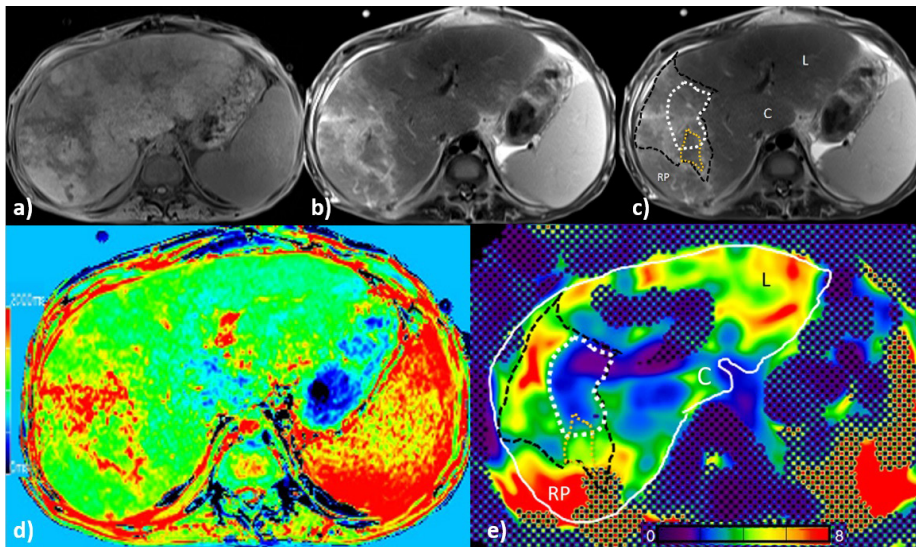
Magnetic resonance (MR) images acquired from a 24-year-old man with occluded right and middle hepatic veins and inferior vena cava. (a) Axial T1-weighted image (T1WI), (b, c) axial T2-weighted images (T2WIs), (d) native B1-corrected variable flip angle (VFA) T1 map, and (e) color elastogram (confidence map). All images are obtained at the same slice level.
